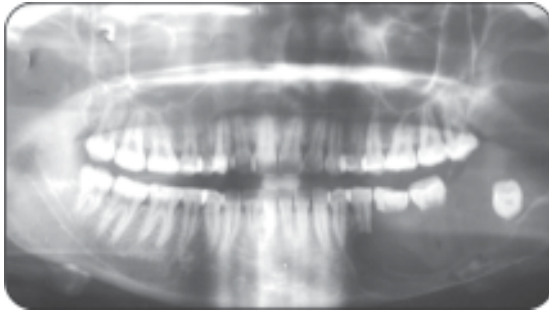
Radiograph of keratocyst
